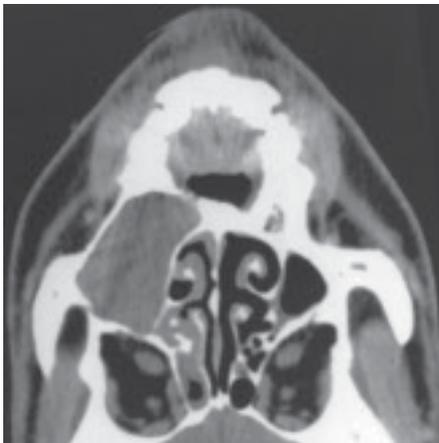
CT of a well-demarcated Schwannoma of the maxilla.
